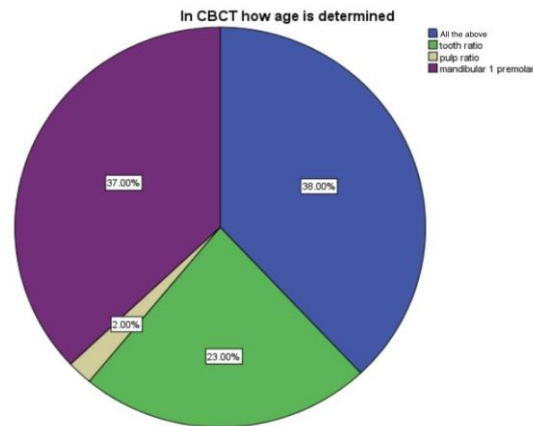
Pie chart shows the percentage of how CBCT is useful in determining the age. In that, 23% said that it is by tooth ratio, 2% said that it is by pulp ratio, 37% said that it is by mandibular 1st premolar and 38% said that it is by all the above. In this green indicate tooth ratio, grey colour indicate pulp ratio, purple colour indicate mandibular 1st premolar and blue indicate all the above.
